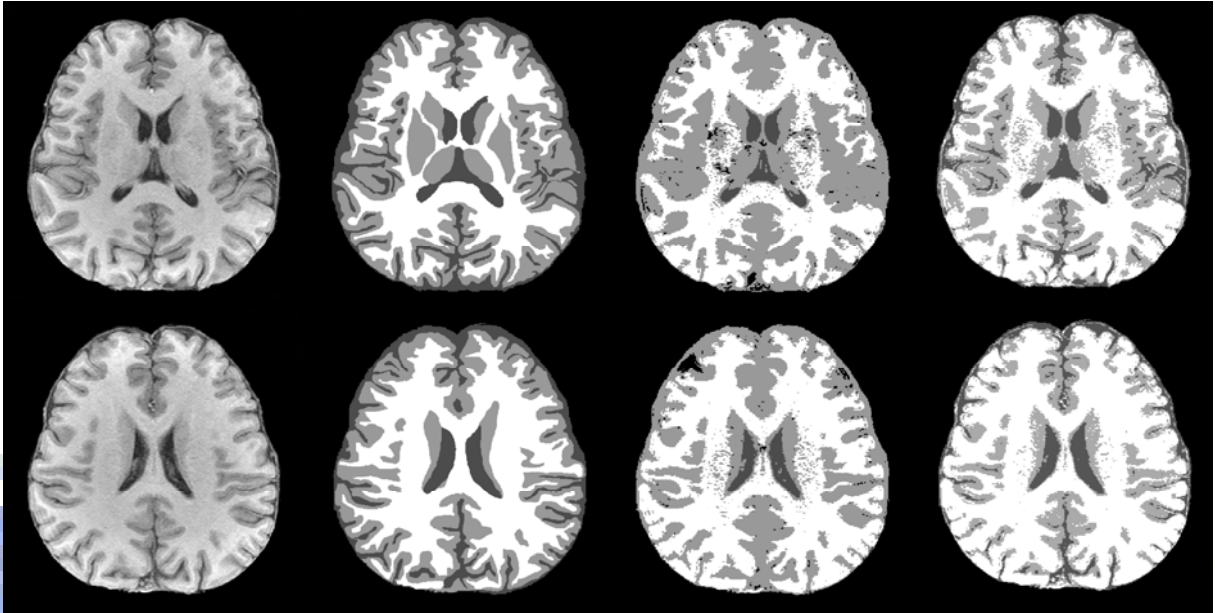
depicts segmented images using the boosted decision tree and the other segmentation algorithm. Images in rows 1 and 2 of Figure 4.9 were obtained from subjects A and B. Images in column 1 of Figure 4.9 show the original MR images from subjects A and B. Images in column 2 of Figure 4.9 show images corresponding to column 1 that were segmented using the boosted decision tree with spatial features  $(G, x, y, r, \theta)$ . Images in column 3 of Figure 4.9 show images segmented with the SRG algorithm. Images in column 4 of Figure 4.9 show images segmented with the AS algorithm. Clear tissue regions were identified from real segmented brain image data using the boosted decision tree, whereas
